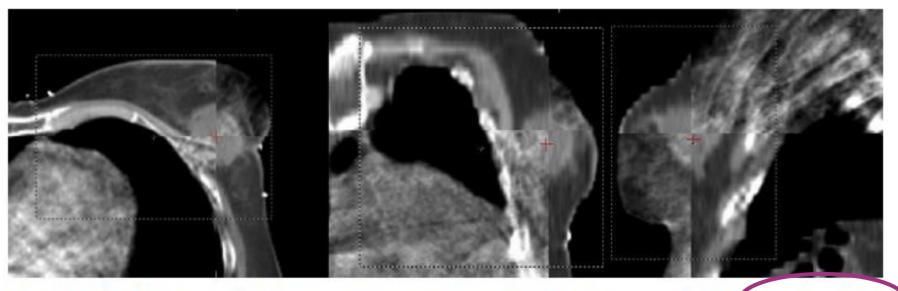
Match of planning computed tomography (CT) and cone-beam CT (CBCT) images after bory (stemum and rib) anatomy registration. A bony anatomy rigid registration was performed based on image data in a user defined, three-dimensional, box-shaped region of interest (white dashed line) using a chamfer matching algorithm.
